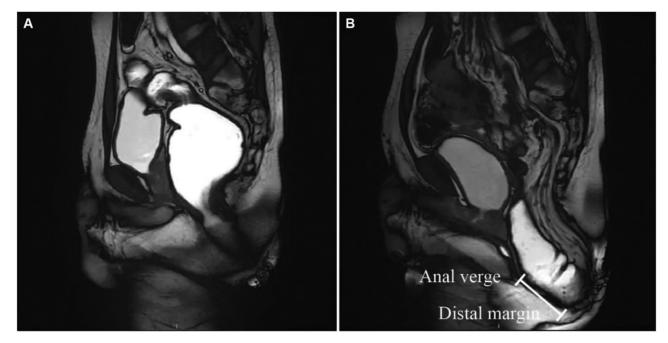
Measurement of external rectal prolapse (ERP) length on magnetic resonance imaging. ERP length was defined as the distance from the distal rectum margin to the anal margin when straining during defecation.
